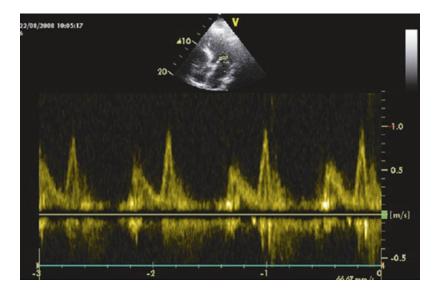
Pulsed wave Doppler image of transmitral diastolic flow: inversion of the *E/A* wave. Apical four-chamber view (TTE). Pattern 2. Impaired relaxation. (From Sarti with permission)
